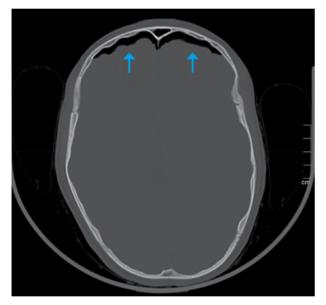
Skull radiography, coronal plan, showing air inside the intracranial cavity with bilateral frontal expression (blue arrows).
